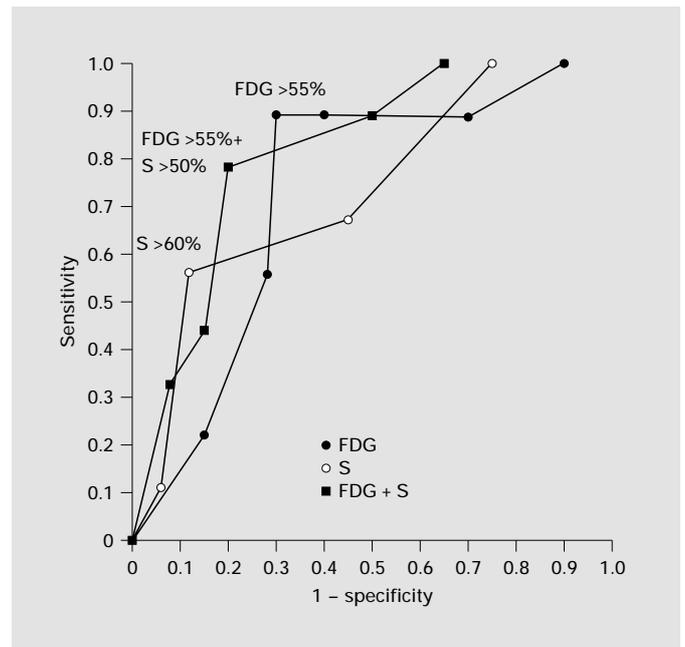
Receiver-operating characteristic curve analysis to predict functional recovery in 34 patients with patent target vessel at follow-up by nuclear studies. For glucose metabolism, an FDG uptake >55% was the optimal cutoff. For imaging of perfusion, a ^{99m}Tc sestamibi (S) uptake >60% was the best cutoff to predict functional recovery. Interestingly, a similar test performance was found for FDG and ^{99m}Tc sestamibi imaging with an area under the curve of 0.73 and 0.74, respectively. Test accuracy was optimized by a concordant match of both tracers, resulting in an area under the curve of 0.81.
